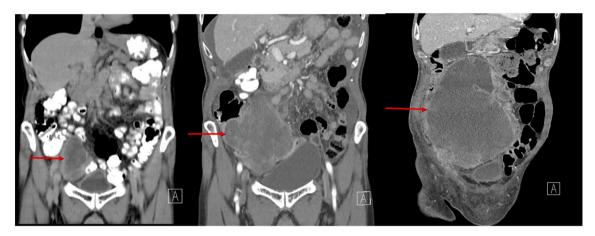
Coronal CT scan of the abdomen over six weeks prior to the surgery.
